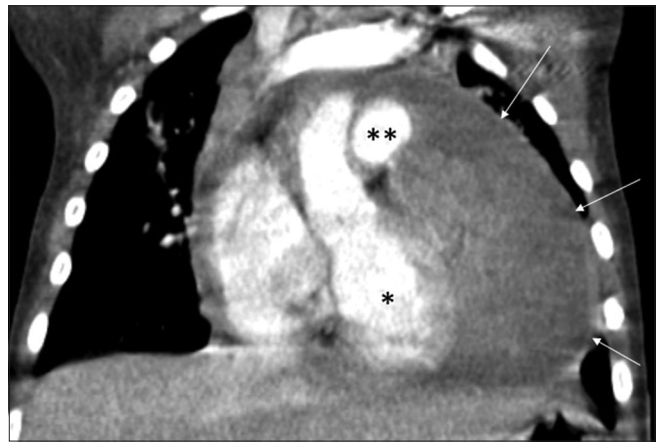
Coronal computed tomography, large pericardial mass (arrows), compressing the left ventricle (*) and pulmonary artery ()
